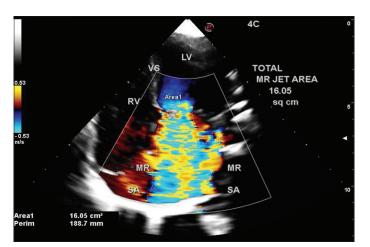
Apical 4 ch view – huge mitral regurgitation jet of size 16.05 sq cm is evident, nearly occupying 50% of single atrial cavity
